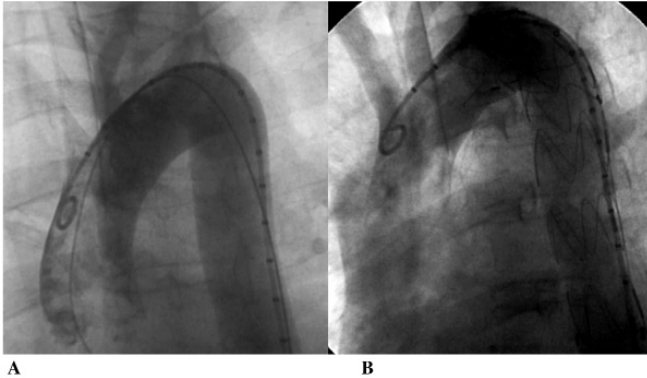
A, Perioperative angiographic scan of the injured segment of aorta with no evidence of extravasation, which has been clearly demonstrated on the computed tomographic scan. B, Completion angiographic scan of the endovascular stent with no endoleak.
